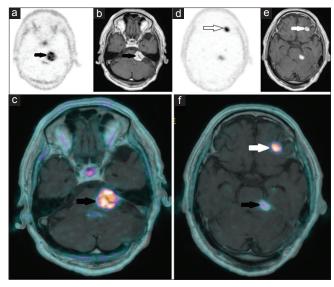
Positron emission tomography/computed tomography showing high grade of 18F-choline uptake (black arrow) in the left cerebellopontine neuroma (a-f) and in the left frontal meningioma (white arrow) (d-f)
